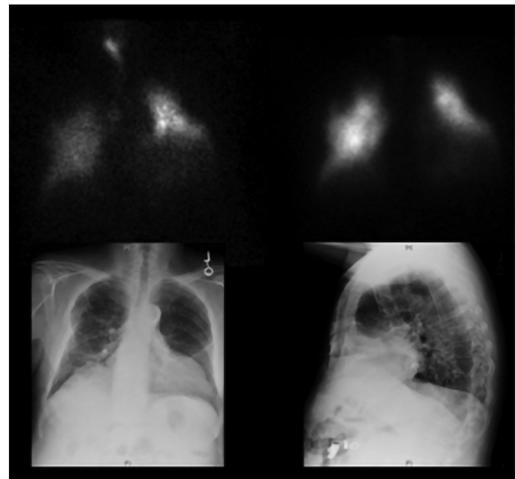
An 86-year-old man with a history of chronic lung disease (CLD) matched small segmental defects in the lung apices corresponding to a large apical bullous seen on the chest radiograph = low likelihood ratio for recent pulmonary emboli.
